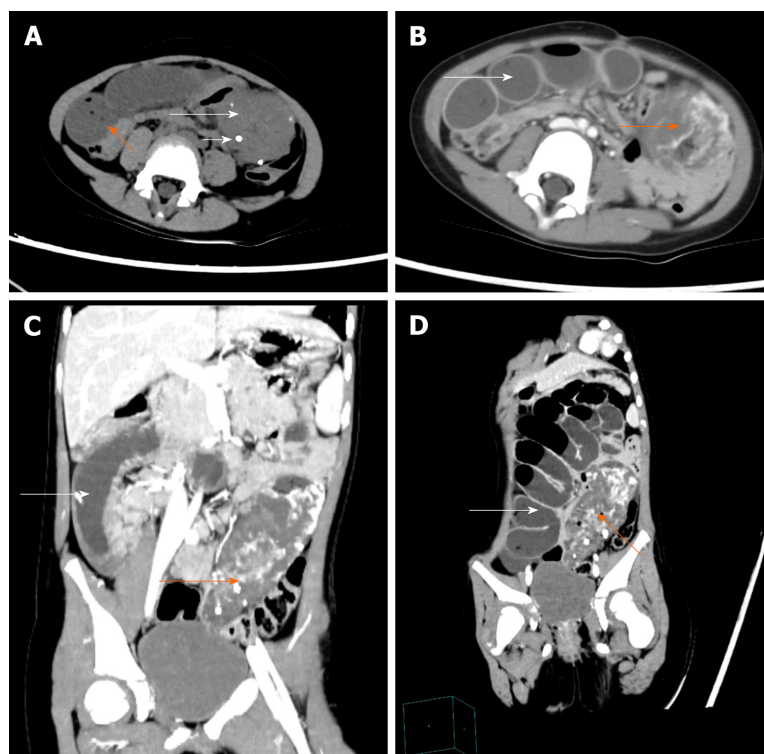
Pre-operative abdominal computed tomography and contrast-enhanced computed tomography images. A: Abdominal computed tomography image showing an ill-circumscribed mass of mixed density in the left lower abdomen (long white arrow) with proximal small bowel dilatation (orange arrow) and multiple nodes with high density in the mass (short white arrow); B-D: Abdominal contrast-enhanced computed tomography images revealing that the mass exhibited heterogeneous enhancement following contrast administration and there were thick and roundabout blood vessels in the mass (orange arrow). There were multiple dilated intestines and air-fluid level within the intestine (white arrow).
